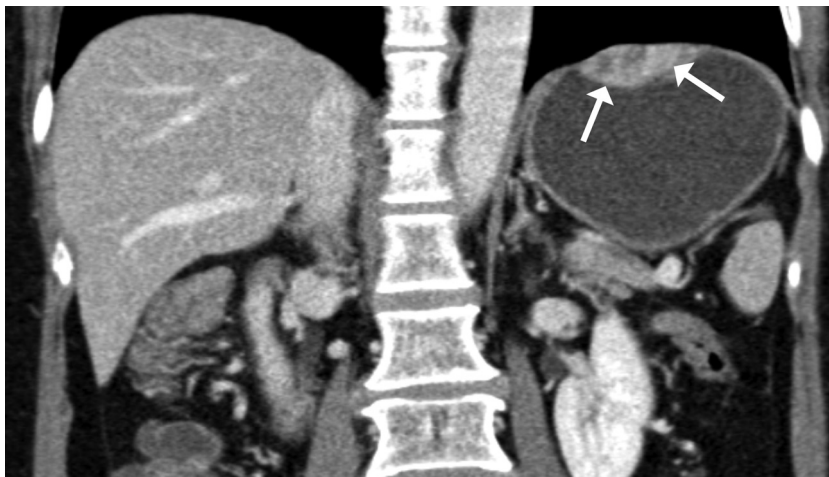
Preoperative CT image of the first tumour. Coronal view.
